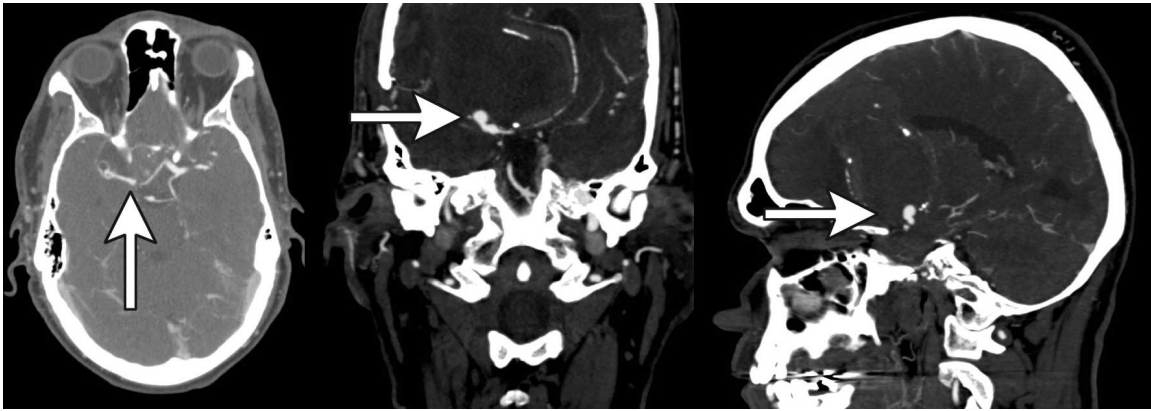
Postoperative computed tomographic angiogram (axial, coronal and sagittal views) showing near complete obliteration and thrombosis of the aneurysm (arrows).
